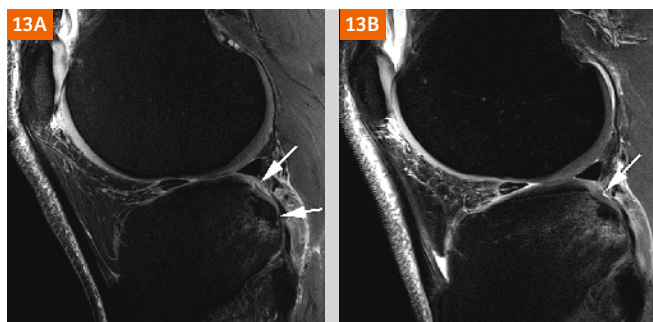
Osteochondral fracture. (13A) 7T sagittal proton density-weighted image shows an osteochondral fracture of the posterior lateral tibia with definite surface disruption of the chondral articular surface and slight depression of the osteochondral fragment (arrows). In addition, there is concomitant traumatic bone marrow lesion. (13B) Corresponding 3T MRI shows osteochondral fracture but differentiation between articular surface depression with a preserved chondral surface from chondral surface disruption is not possible (arrow). Bone marrow lesion appears more pronounced at 3T compared to 7T MRI.
